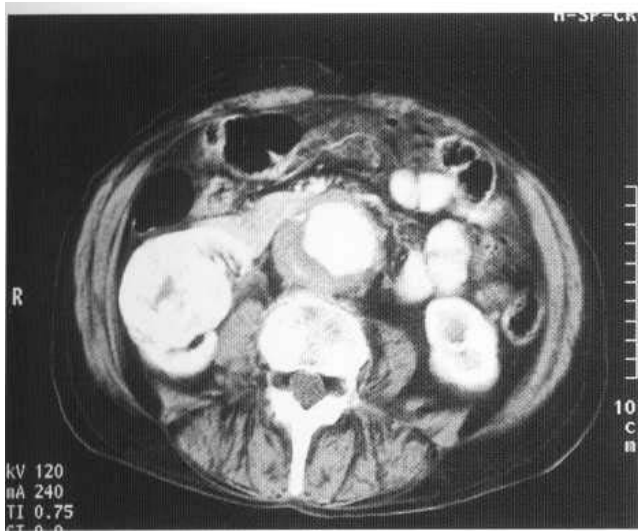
Renal oncocytoma on CT appearing as a well-defined intensely enhancing mass with central non-enhancing scar.
